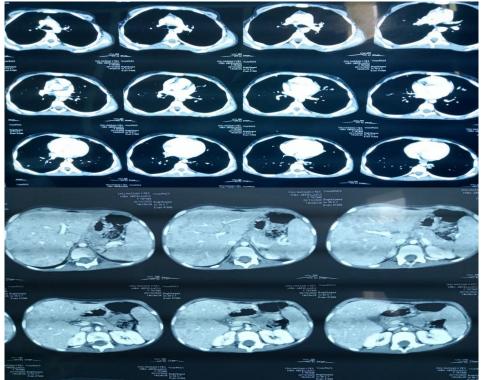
A thoraco-abdomino-pelvic CT scan. Carried out in the radiology department of the CHU-Hassan II in Fez.
